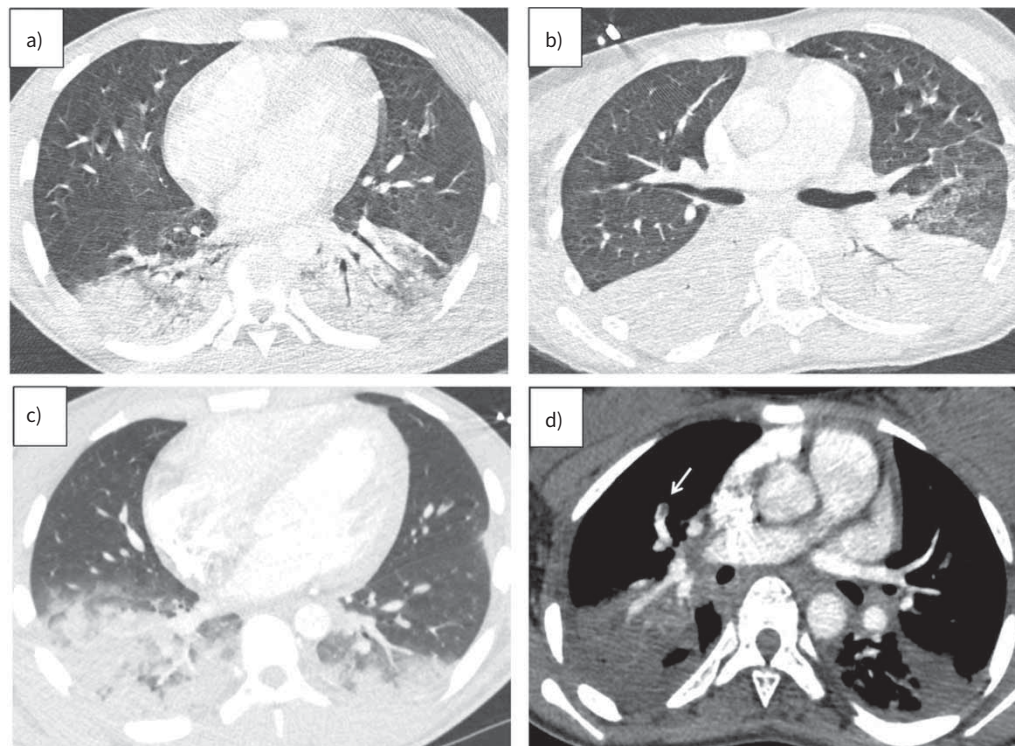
Typical high-resolution computed tomography (HRCT) of the chest of patients with severe acute chest syndrome included in the study. a) Axial HRCT image of the middle lobe, lingula and lower lobes in a 19-year-old male showing alveolar consolidation with air bronchogram and ground-glass opacities in the lower lobes. b) Axial HRCT image of the middle lobe, lingula and lower lobes, in a 26-year-old female showing alveolar consolidation with air bronchogram in the lower lobes. c) Axial HRCT image of the middle lobe, lingula and lower lobes in a 19-year-old male showing alveolar consolidation and ground-glass opacities in the lower lobes. d) Axial contrast-enhanced HRCT image of the upper lobes in an 18-year-old female showing a segmental pulmonary embolism in the right upper pulmonary artery and alveolar consolidation in the upper lobes.
